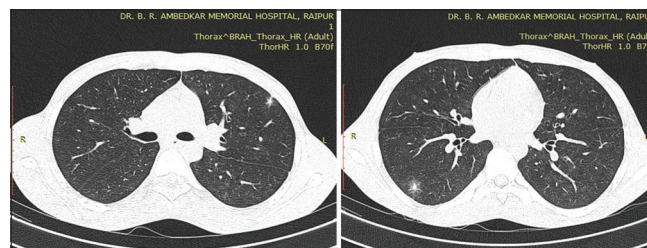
Axial HRCT images showing nodules surrounded by ground-glass opacity (CT-halo sign) in a case of angioinvasive aspergillosis
